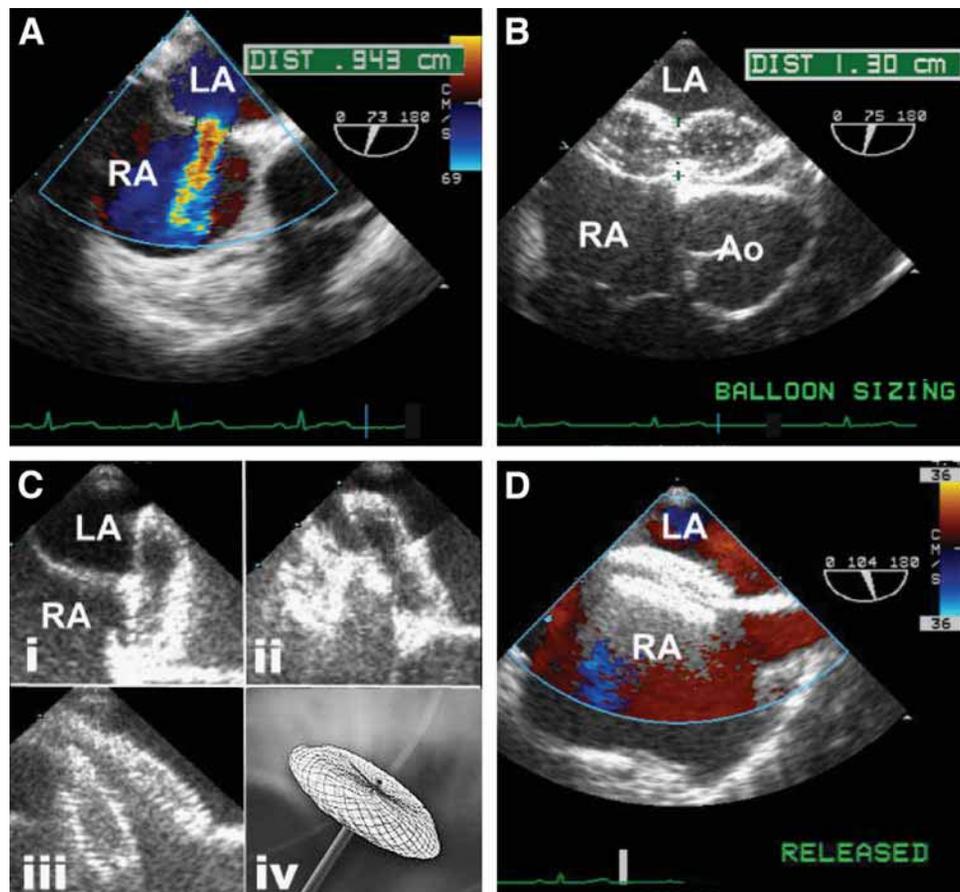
Stages of percutaneous closure of a secundum atrial septal defect (ASD; A) using an Amplatzer device are shown on transesophageal echocardiography guidance. Balloon sizing of the defect (B) is followed by sequential deployment of the left atrial and right atrial arms of the device (C) (picture insert: AMPLATZER® Septal Occluder ASD). Following release of the device, interrogation of the closure was performed using Color Doppler (D) and agitated saline contrast. (Please *see* companion DVD for corresponding video.)
